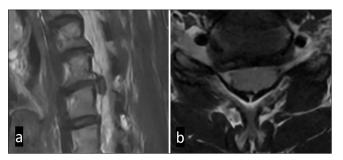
Preoperative cervical magnetic resonance imaging (MRI). (a) Sagittal T2-weighted MRI shows a herniated disc that has migrated downward from the C5/6 disc level to the inferior border of the C6 pedicle. (b) Axial T2-weighted MRI shows that the herniated disc is located in the right paramedian region, causing compression of the nerve root.
